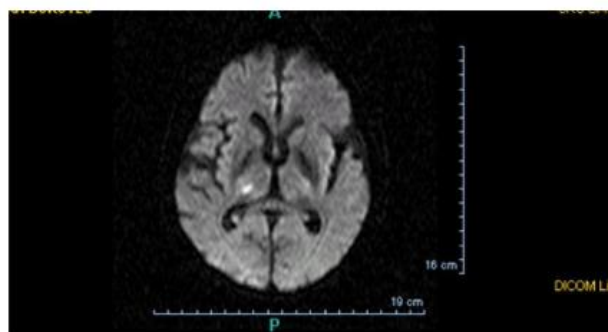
Lacunar infarct on brain MRI (diffusion-weighted).¹²
